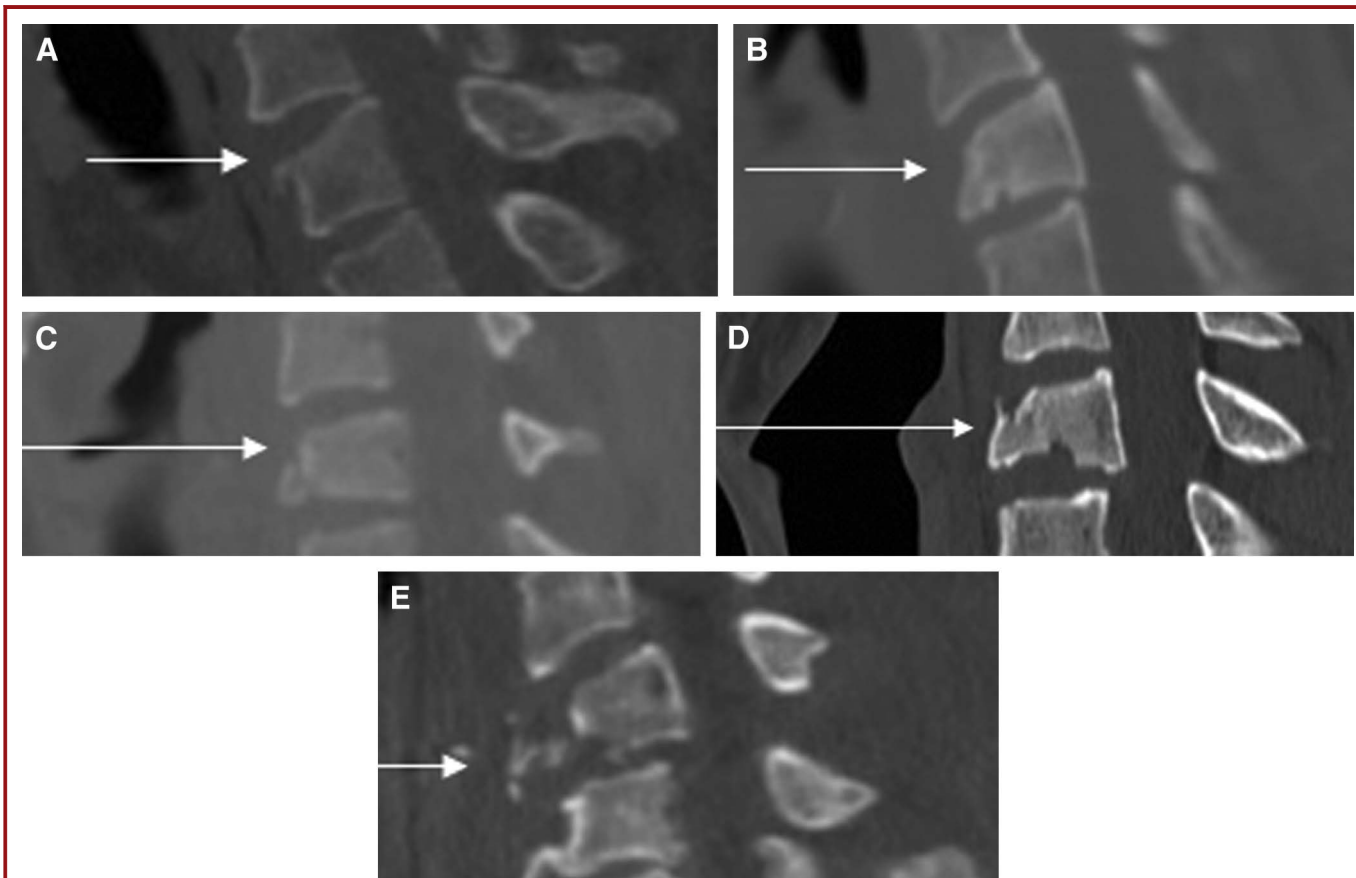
Reformatted sagittal computed tomographic views (A-E) of cervical spine indicating compressive flexion (CF) phylogeny stages 1 to 5 of Allen et al Classification. CF stage 1 (A) is associated with blunting of the antero-superior end plate of the vertebral body. In CF stage 2 (B) there is a “beak-shape” deformity of the vertebral body without translation. In CF stage 3 (C) there is a “broken beak” of the vertebral body without translation. CF stage 4 (D) indicates a broken beak with up to 3 mm translation and in CF stage 5 (E) we have a broken vertebral body with more than 3 mm translation. Stages 4 and 5 are very much reminiscent of “teardrop” fractures.
